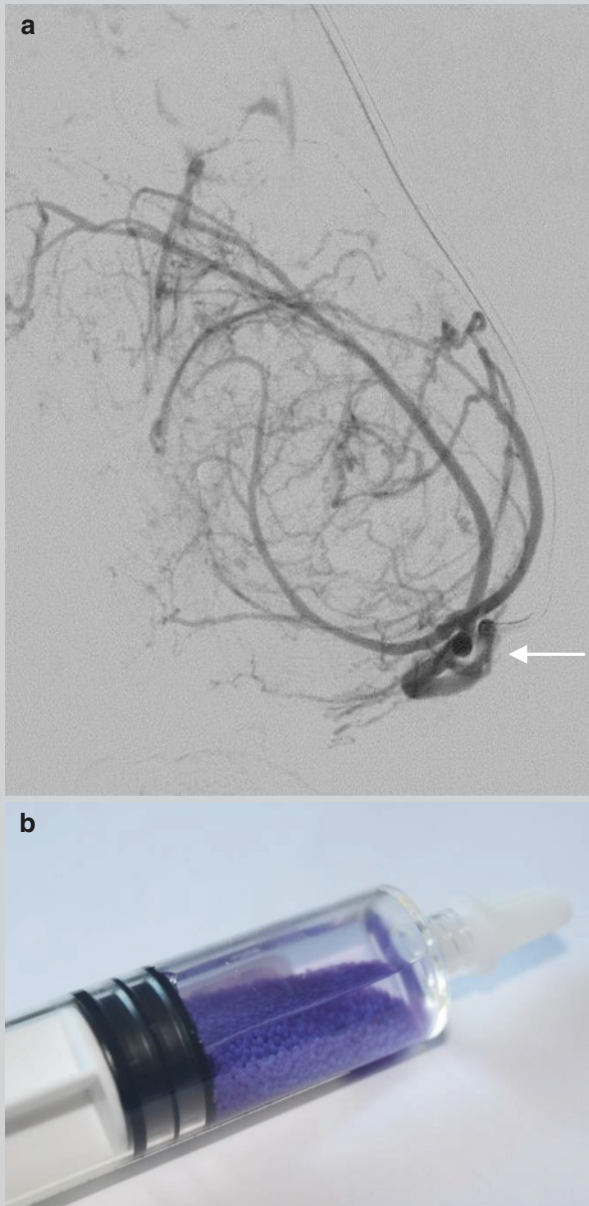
(a) Following arterial access through the right common femoral artery, the left uterine artery (*arrow*) was selectively catheterised with a microcatheter and angiography confirmed avid vascular supply to the enlarged fibroid uterus. (b) Both uterine arteries were embolised with permanent calibrated microparticles (700 micron particles in this case). Her symptoms improved within a week of her procedure and a follow-up MRI at 6 months confirmed complete devascularisation of the fibroids with reduction in uterine size
